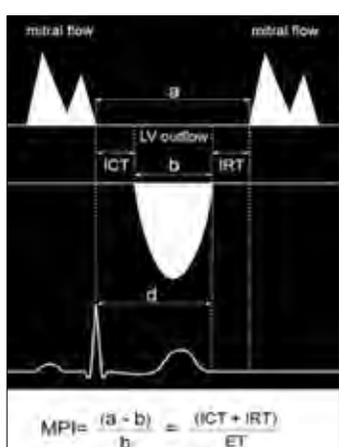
MPI measurement. In the figure, we demonstrated the measurement of MPI by mitral valve and left ventricular outflow flow doppler.
